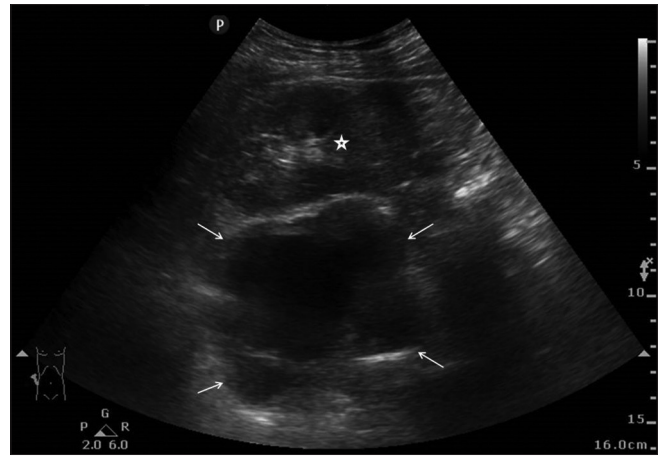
Point-of-care ultrasound image of the transverse plane showing multiloculated cystic mass (arrows) above the upper pole of the right kidney (open star)
